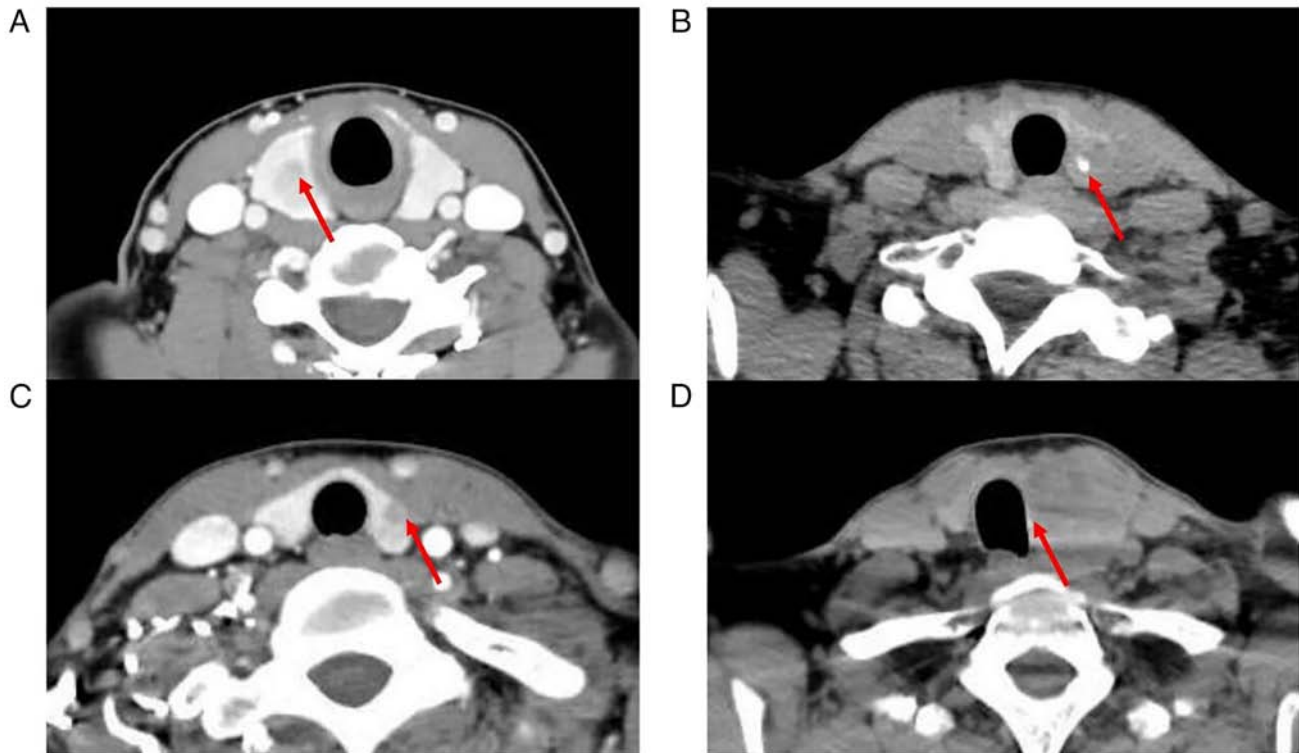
Representative contrast-enhanced computed tomography images. (A) Inhomogeneous enhancement (red arrow). (B) Calcification (red arrow). (C) Capsule invasion (red arrow). (D) Tracheal deviation (red arrow).
